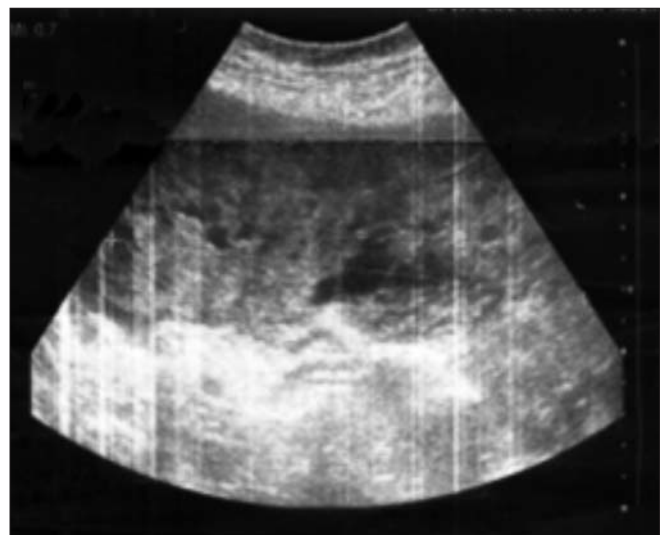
Ultrasound aspect—complex abdominal formation in the left hemiabdomen
